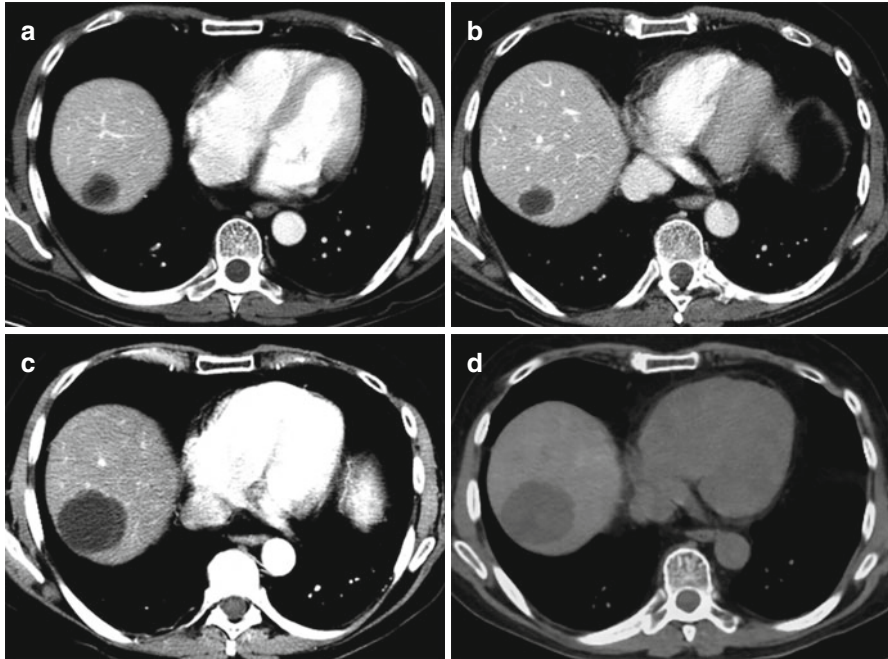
Responding hepatic metastasis with pseudoprogression in a 56-year-old male with duodenal GIST. (a) Pretreatment contrast-enhanced CT shows an enhancing hepatic metastasis in segment 7 with the tumor density measured at 40 HU. Note the peripheral enhancing component. (b) Contrast-enhanced CT image obtained 2 months after treatment demonstrates a minimal decrease in size of the hepatic metastasis but with a significant decrease in CT density (27 HU). The peripheral enhancement is no longer evident. This is typical of responding GIST. (c, d) Contrast-enhanced CT image (c) obtained 7 months after treatment shows a homogeneously hypoattenuating tumor with a continuous decrease in tumor density (18 HU). Notice the significant increase in tumor size with no appreciable glucose uptake on FDG-PET (d). The enlarging homogenous tumor with a continuous decrease in tumor density should not be confused with a progressing tumor. (HU = Hounsfield Unit)
